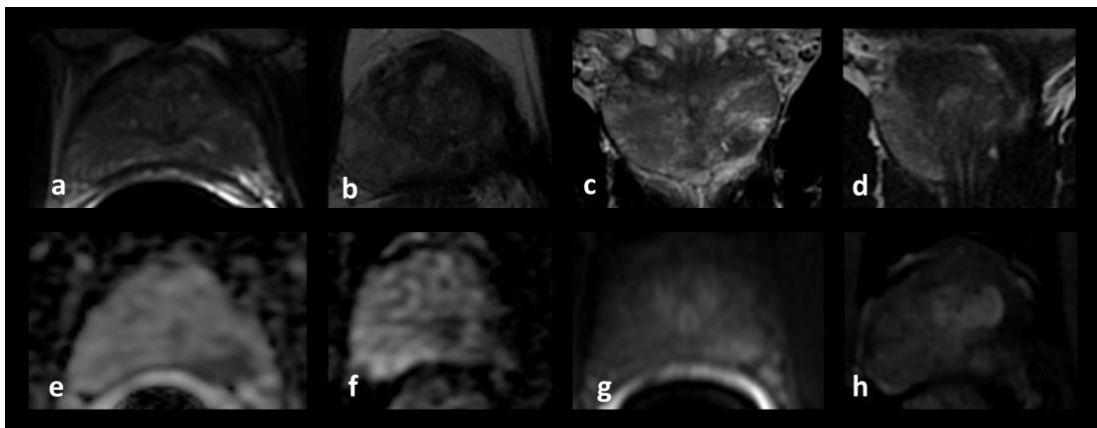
Pre-operative and post-operative multiparametric-MR images.
